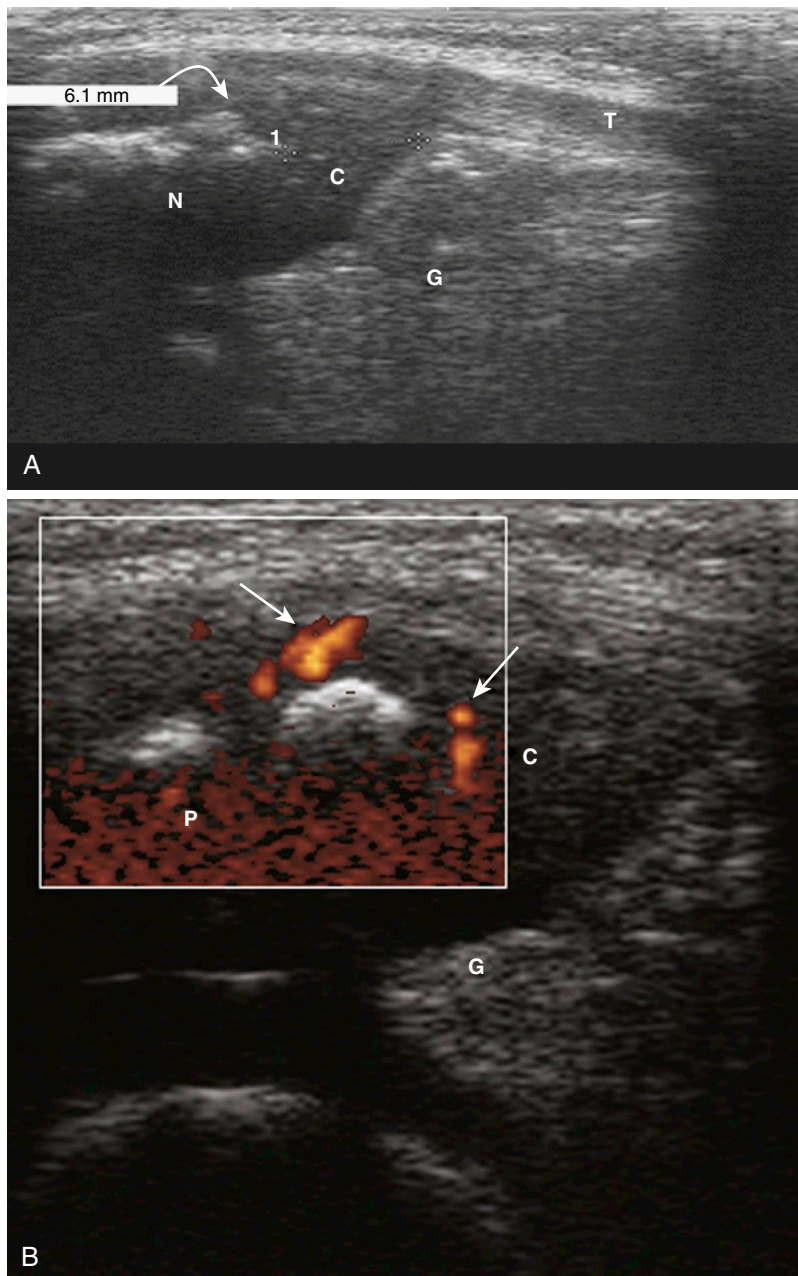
4 A, Ultrasound shows the normal proximal insertion of the patellar ligament in 4-year, 1-month-old girl. Notice the fragmented appearance of the patellar ossification center (*arrow*) and the heterogeneous appearance of the cartilage. C, patellar cartilage; N, ossification center; T, patellar ligament. B, Normal vascularization of the proximal patellar ligament is identified by power Doppler, which shows two vessels (*arrows*) feeding the patellar cartilage. Notice the fragmented appearance of the patellar ossification center.
